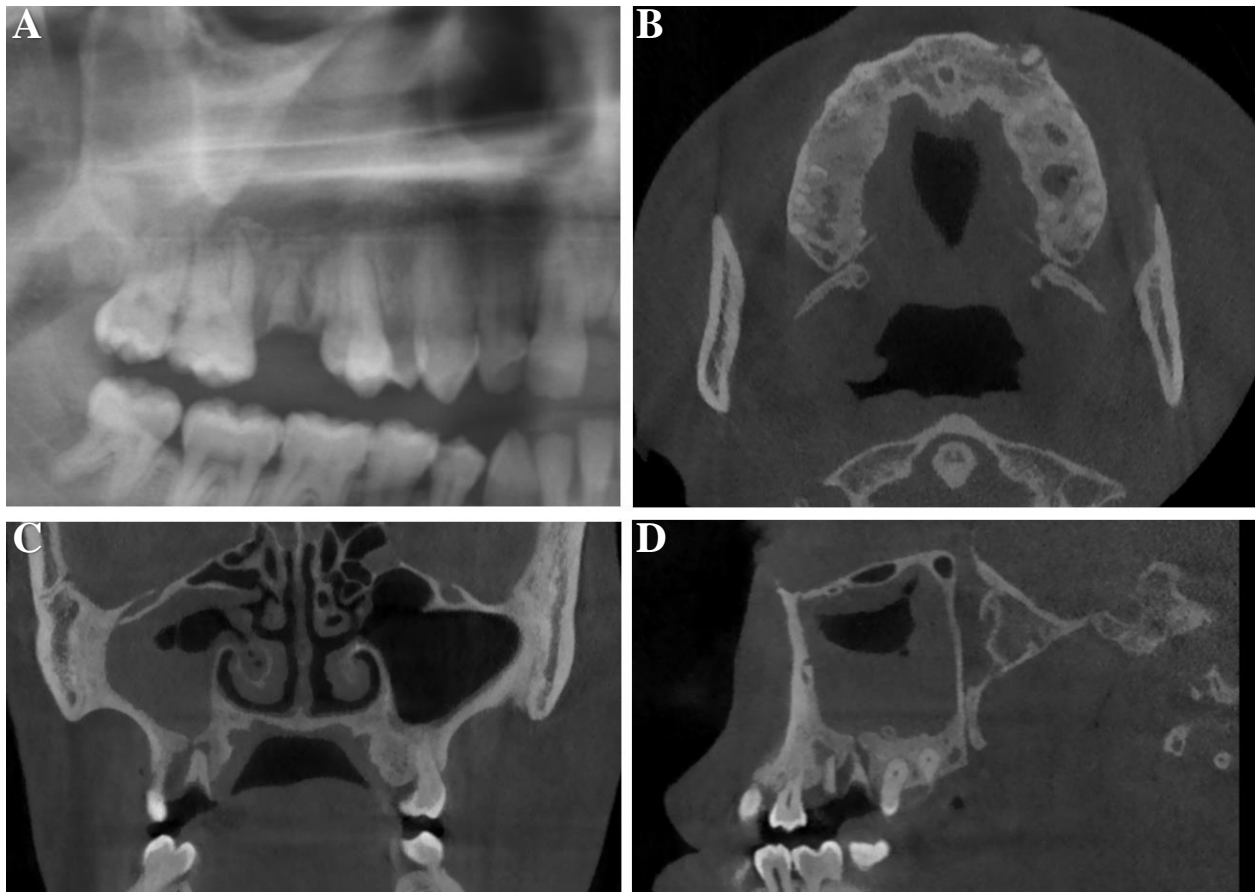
ROI tooth 17. A, cropped PAN depicting a well-defined, corticated, periapical radiolucency at endodontically treated tooth 17 causing elevation of the maxillary sinus floor and discontinuation of the bony margins of the lesion at the superior border. CBCT slices: B, axial, C, coronal, and D, sagittal view. Showing a well-defined periapical low-density with elevation and breaching of the maxillary sinus floor.
